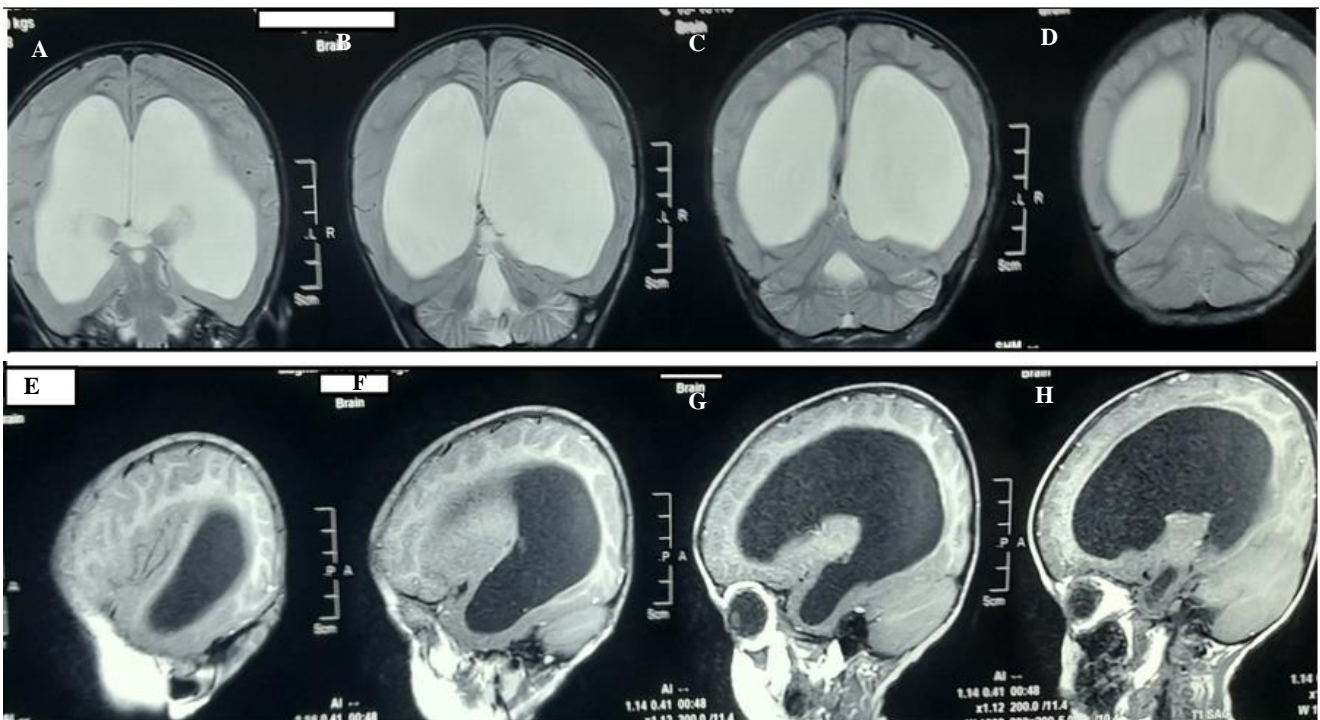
(A-H): Cranial MRI with the contrast of the child showing grossly dilated ventricular system with thinning of the brain parenchyma.
